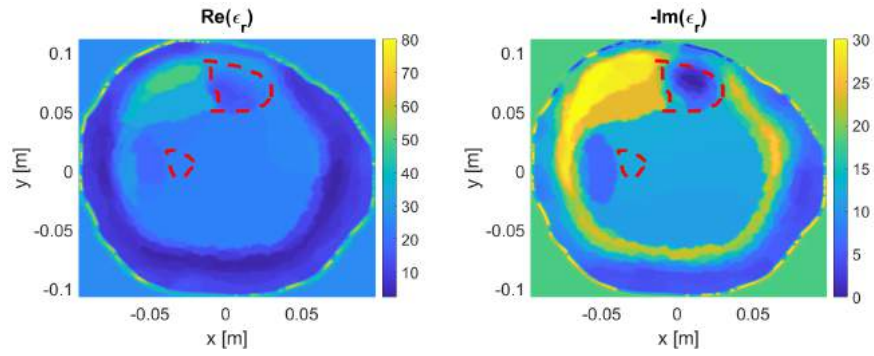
Changing location of antennas to enhance MRI model 1 reconstruction.
